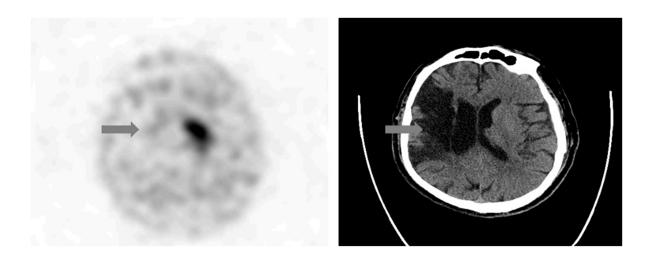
61-year-old male with history of right MCA territory infarct evaluation for RUE tremors for 2-4 months. 5a. Axial brain SPECT showing decreased to absent uptake in the right caudate and putamen (arrow) due to prior right MCA territory infarct. 5b. Axial CT head without contrast showing right MCA territory infarct (arrow).
